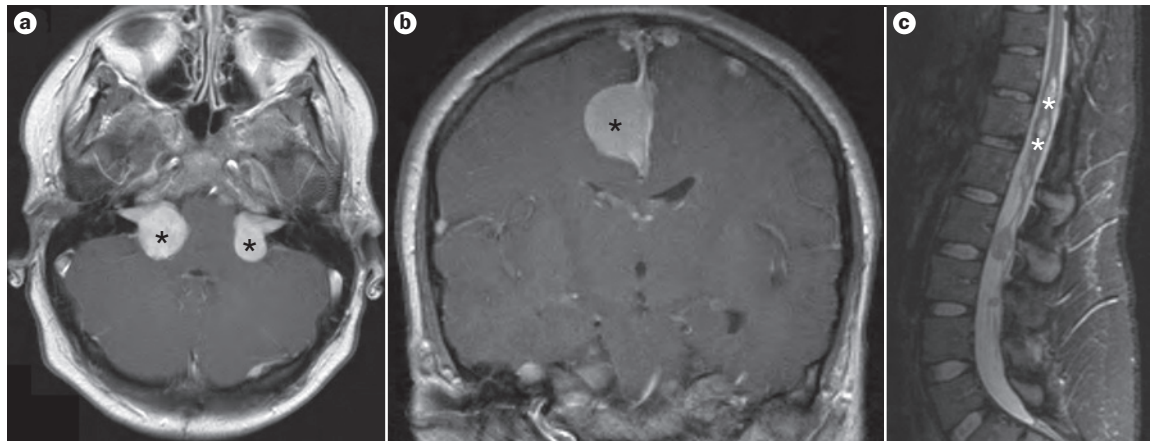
Tumours arising in individuals with NF2. a | MRI shows bilateral vestibular schwannomas (asterisks) in a teenage girl with NF2. b | MRI shows a meningioma (asterisk) in a young girl with NF2. c | MRI shows multiple intraparenchymal spinal tumours, most likely ependymomas, in a young woman with NF2. Abbreviation: NF2, neurofibromatosis type 2.
